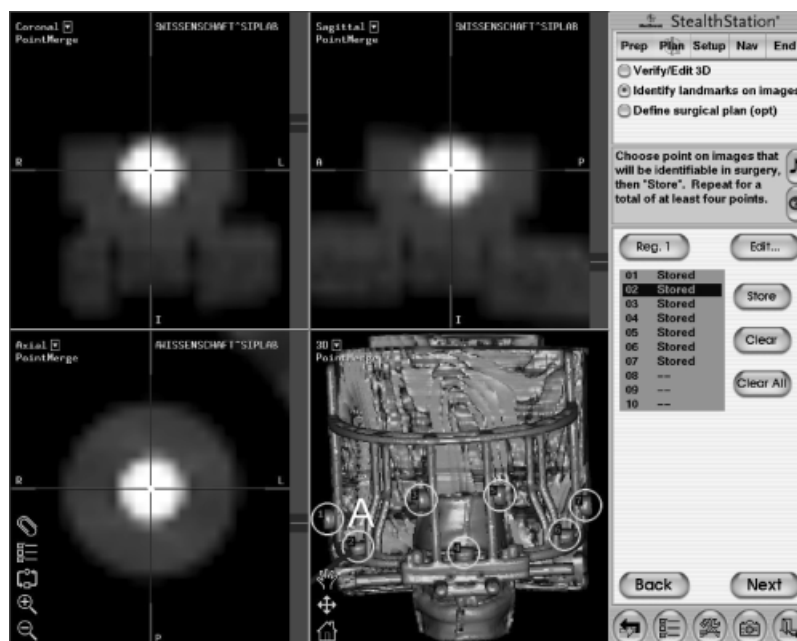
Definition of the seven reference markers of the SIP-Lab reference frame (marker 2 – A) on the axial, sagittal and coronal reformatted computed tomography slices.
